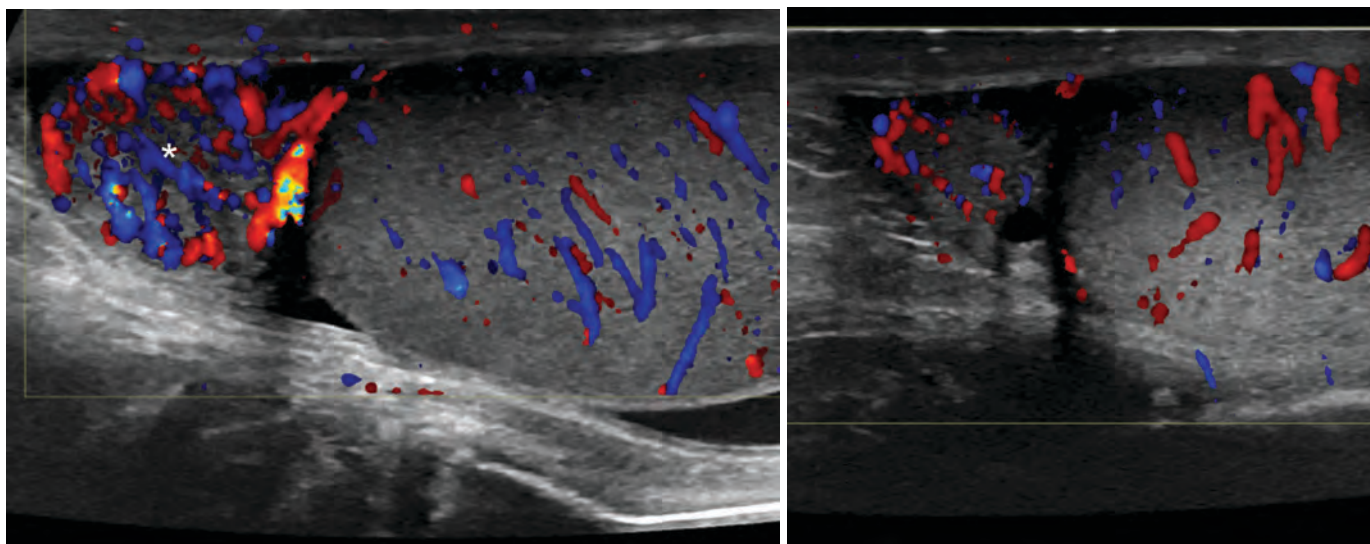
Teenager with left testicular pain due to epididymitis. Color Doppler images of the epididymis and testicle show that the left epididymal head is hyperemic (A, *) compared to the contralateral side (B), while the testicular Doppler flow is symmetric.
